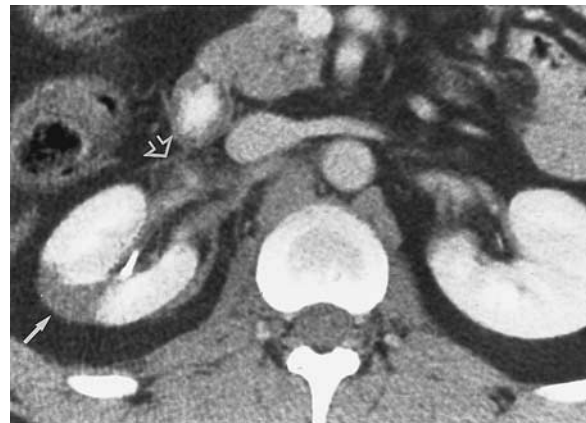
Subsegmental renal infarction (category I) in a 47-year-old man who had sustained blunt abdominal trauma. Contrast-enhanced CT scan demonstrates a sharply demarcated, wedge-shaped area of decreased attenuation in the interpolar region of the right kidney (solid arrow). Note also the evidence of subtle hemorrhage in the right renal hilum (open arrow).
